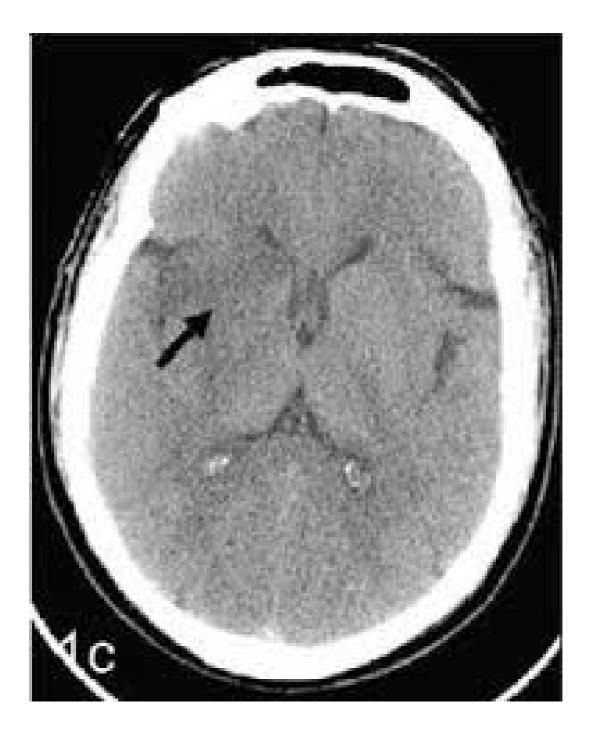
CT scan showing insular ribbon sign
